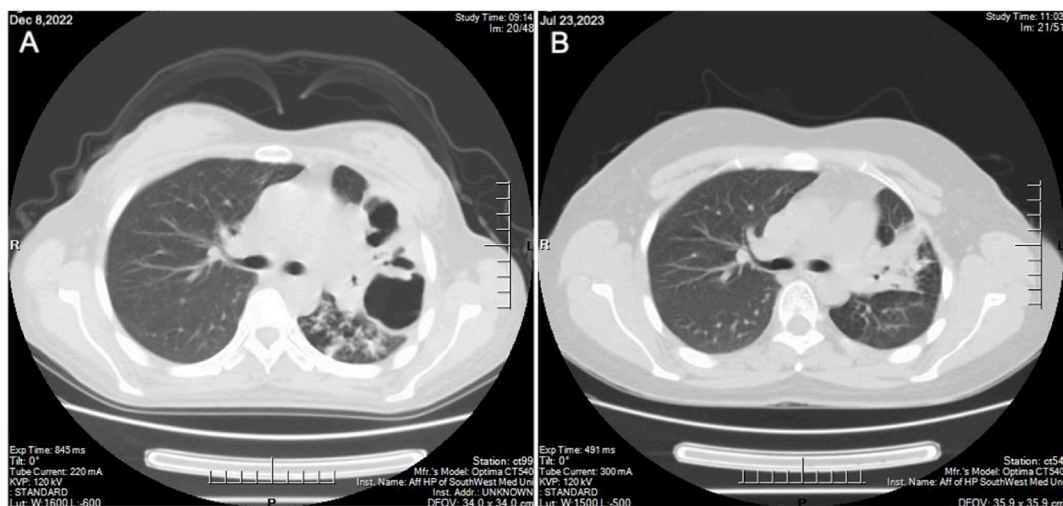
Changes in CT scan A and B showed that the lesions in both lungs were significantly reduced, the cavities were shrunk, and part of the lung tissue had expanded after treatment.
